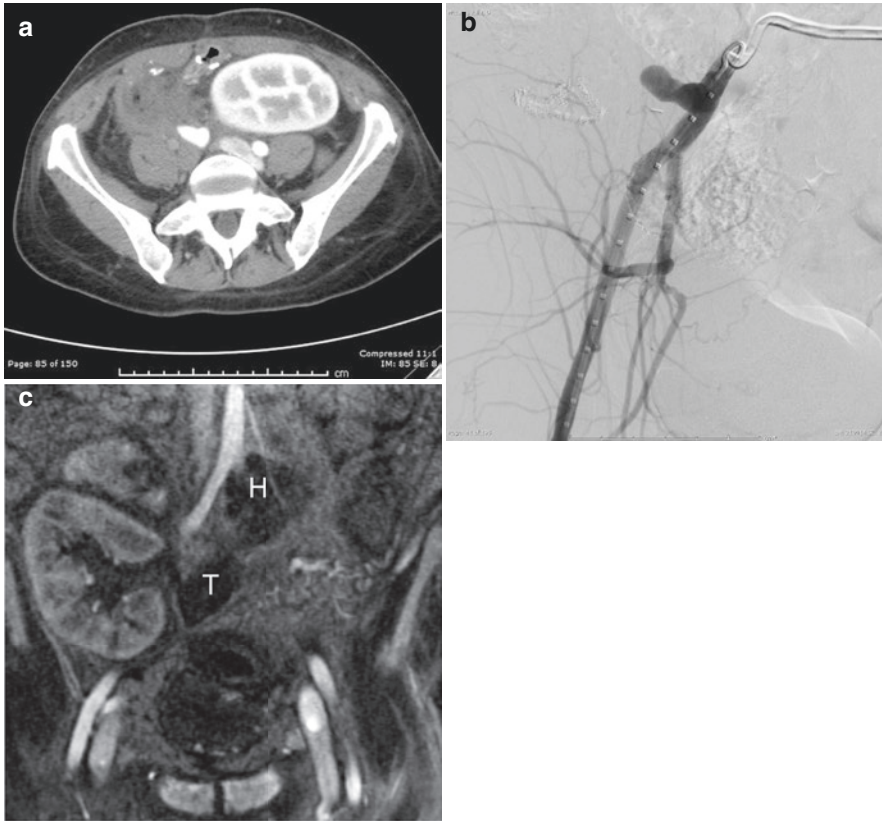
(a) Axial contrast-enhanced CT of the kidney transplant in the left iliac fossa. There is complete occlusion of the transplant artery (black arrow) causing non-enhancing heterogeneous transplant pancreas (P). If undetected early, this results in transplant necrosis. (b) Conventional arteriogram of the iliac artery shows complete occlusion of the Y graft (arrow). (c) Coronal MR angiography image of the pelvis during arterial phase shows no enhancement within the head (H) and tail (T) of the pancreas transplant
